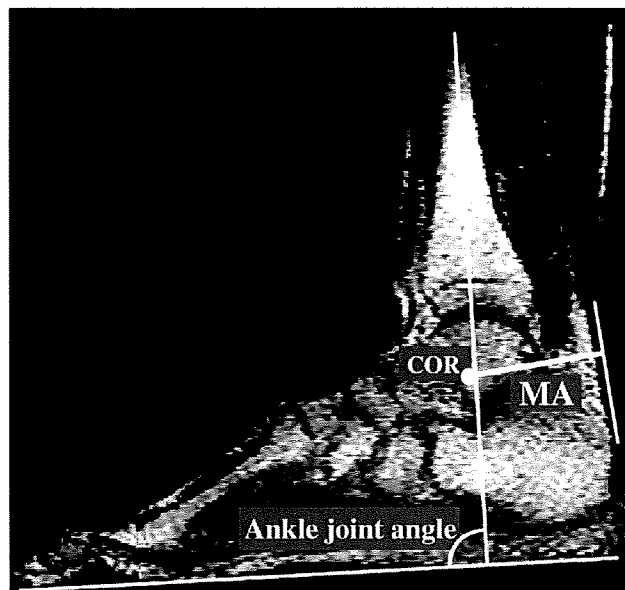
A typical magnetic resonance image of the ankle joint. Achilles tendon moment arm (MA) was determined by the distance between the center of rotation (COR) and the line through the middle of Achilles tendon. The ankle joint angle was defined as the angle formed by the longitudinal axis of the tibia and sole of the foot.
